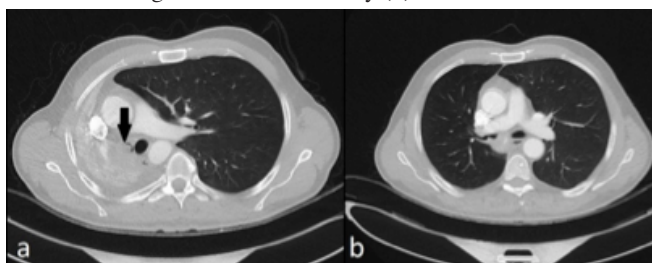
The total atelectasis of the right lung, mediastinal shifting and endobronchial tumor (black arrow) were seen in computed tomography (a), the ventilation of the right lung and partial patency of the right bronchus (b).
